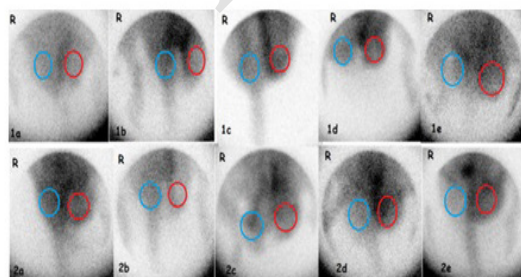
Testicular scintigraphy using ^{99m}Tc pertechnetate; one day sham control (1a), torsion (1b), melatonin (1c), PMF (1d), melatonin plus PMF (1e), and one week sham control (2a), torsion (2b), melatonin (2c), PMF (2d), melatonin plus PMF (2e).
